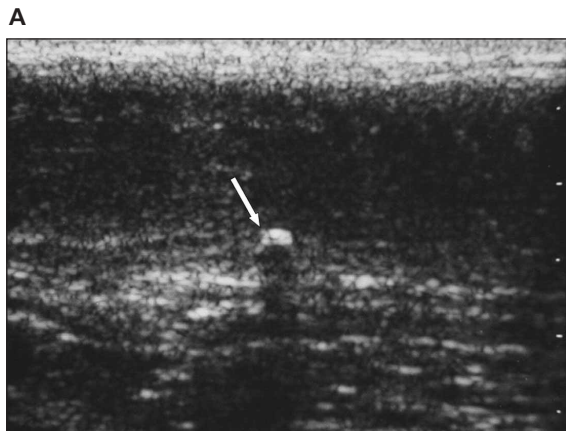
Small echogenic plaque causing lateral curvature. A, Longitudinal sonogram, oblique dorsal access (from the midline to the left lateral face of the penis). The lesion (arrow) produces a small acoustic shadow. B, Axial sonogram, oblique access. The plaque is lateral and a bit larger in the transverse plane (arrow). C, Axial sonogram, right lateral access with mild compression. The lesion can be totally examined. There is a lack of acoustic attenuation due to the compression.
